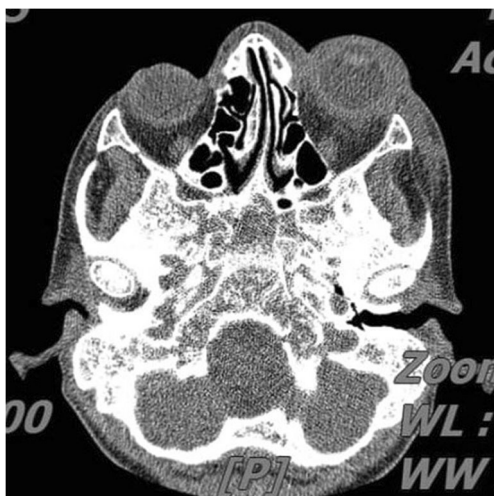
A 24-year-old man, with a known case of thalassemia major; orbital CT scan with contrast coronal view at presentation revealed clear sinuses and mild proptosis of the left eye with increased thickness of the posterior sclera
